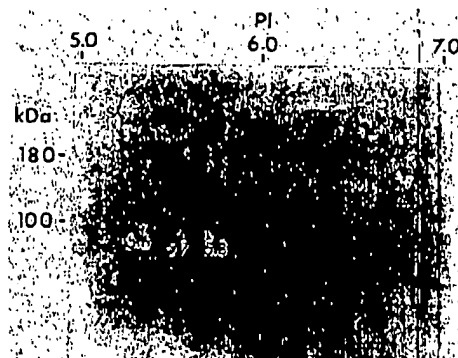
Two-dimensional gel electrophoresis of affinity-purified PSMA. Ten micrograms of purified PSMA was analyzed as described in Material and Methods. Arrows indicate the isoelectric points of 5.6, 5.7 and 5.8 showing identical spots for both the 100 and 180 kDa species.
